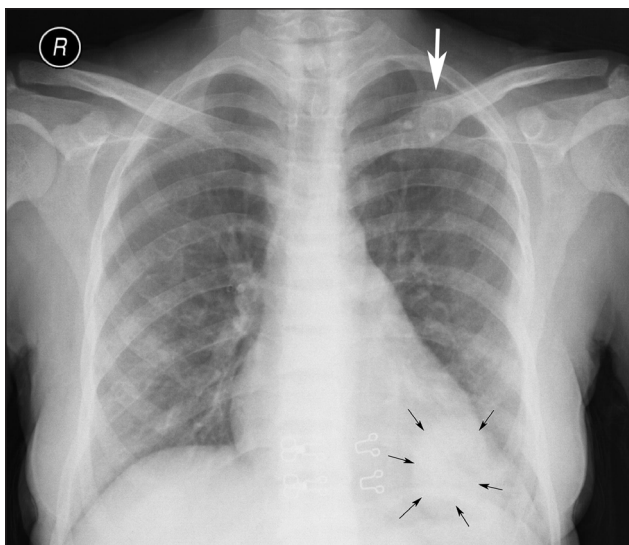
Plain chest X-ray showing a radiopaque lesion on the left posterior of the 10th rib (black arrows) and an expansile lytic lesion of the left clavicle (white arrow).
